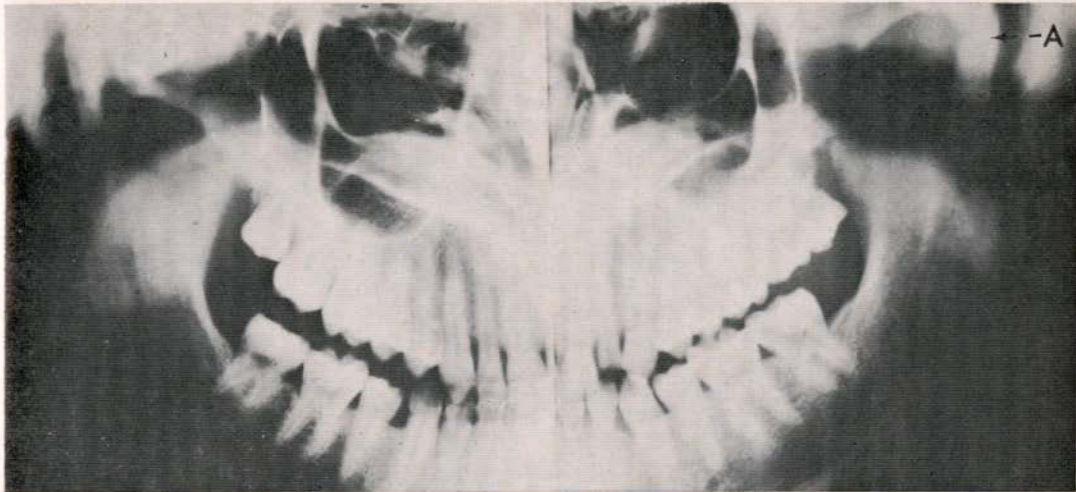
Panoramic Radiograph showing fracture of the left Condyle (A). □
